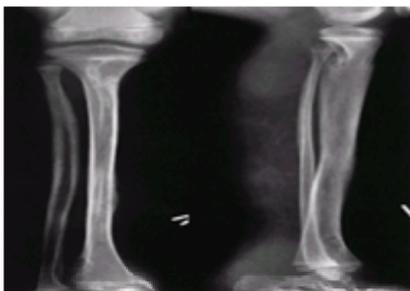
Neurofibromatosis in a 10-year-old patient. The radiograph shows an array of cystic and scalloped skeletal lesions in the tibia and os calcis of the right leg. Some of the lesions are characteristic of neurofibromatosis. Other lesions, occurring in isolation, can mimic benign fibrous tumors. Scalloped cortical erosion at the upper end of the femur, permeative bone destruction in the region of the os calcis, and metaphyseal cystic lesions are other features. (From ref. [1](#), with permission.)
